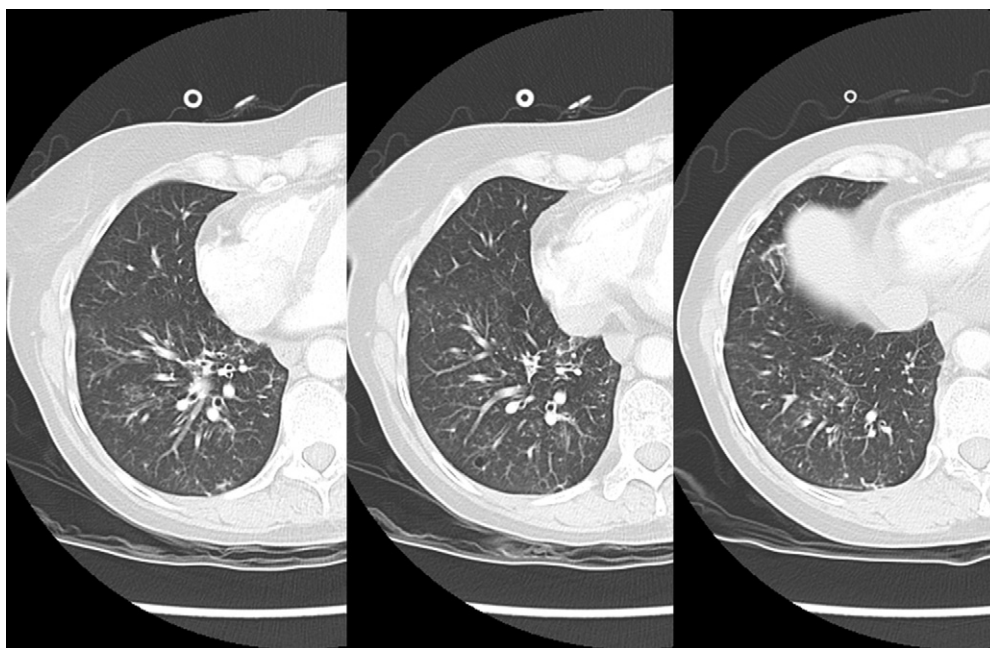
Thoracic computed tomography showing bronchioalveolar micronodulae in the lower lung zone. Scanner thoracique montrant des micronodules bronchiolo-alvéolaires lobaires inférieurs.
